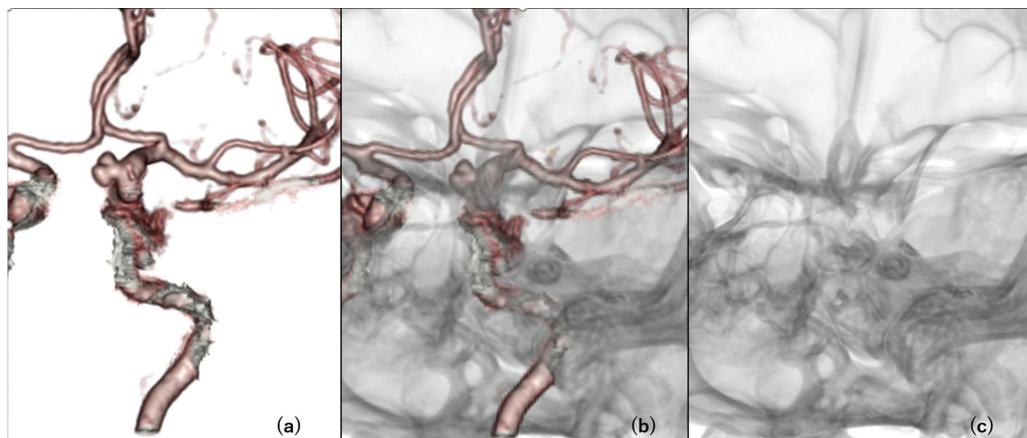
(a) Optimal working angle for coil embolization was identified on 3D CT angiography images. (b) Fusion image shows relationship between intracranial artery and skull. (c) Skull image was derived after removal of arterial data in same angle with optimal working angle.
